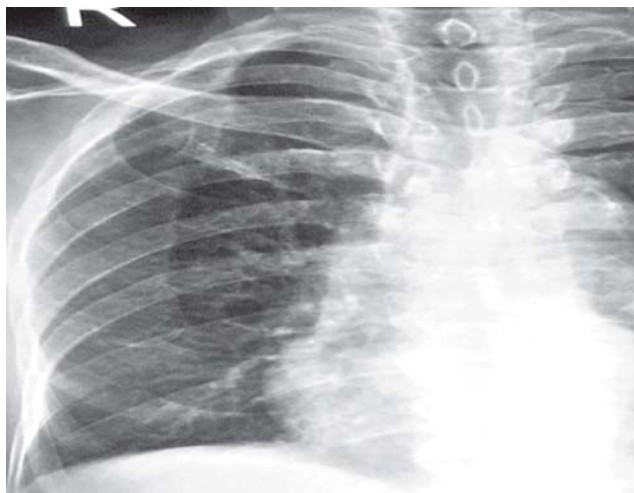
Chest radiograph (post surgical repair) showing resolution of the right-sided pleural effusion.
